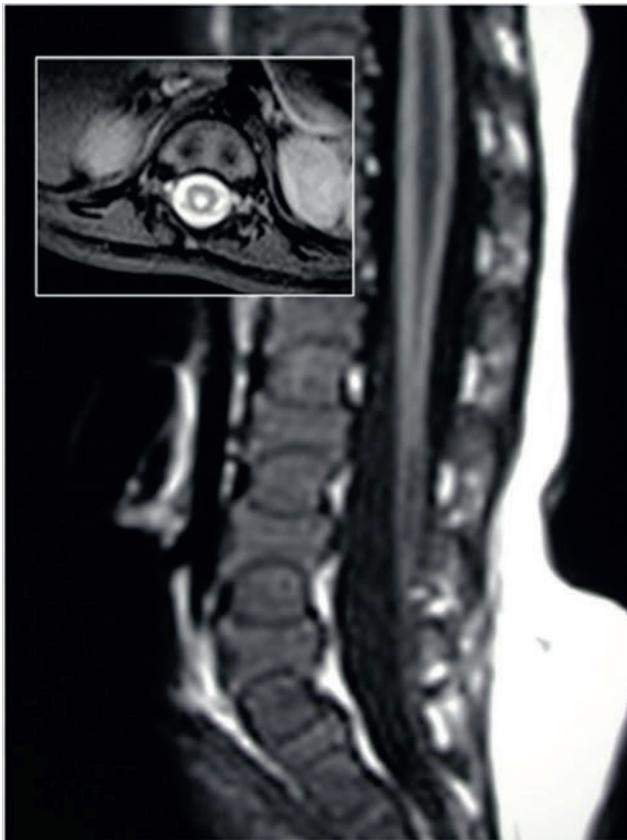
Magnetic resonance image of the lumbar spine of an infant with a moderate-size syrinx and a conus tethered by a thickened filum. Insert shows the extent of the syrinx in the transverse plane.
